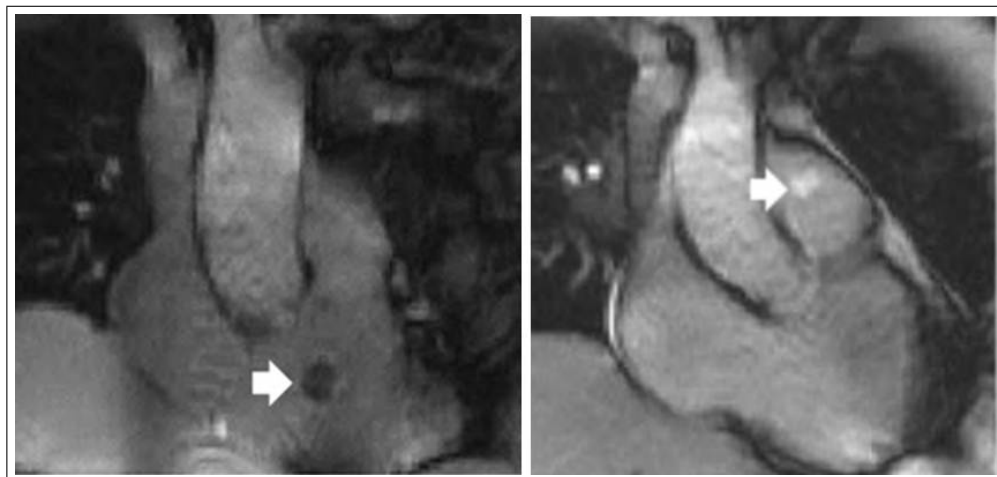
Magnetic resonance imaging catheterization using an air-filled (A) and gadolinium-filled (B) balloon catheter. White arrows indicate catheter tips when entering the main pulmonary artery from the right ventricle [33].
